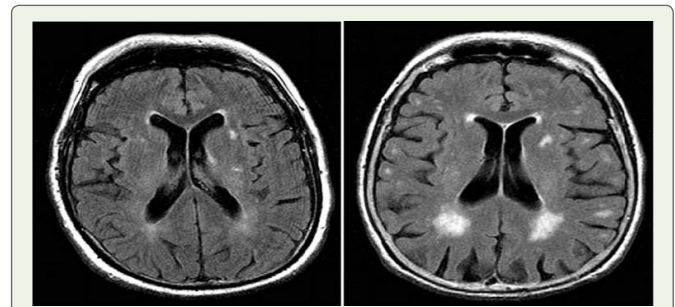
MRI Findings T2/Flair-periventricular hyperintensities unremarkable for cerebello-pontine T2 hyperintensities. (likely due to the disease's rapid progression)
